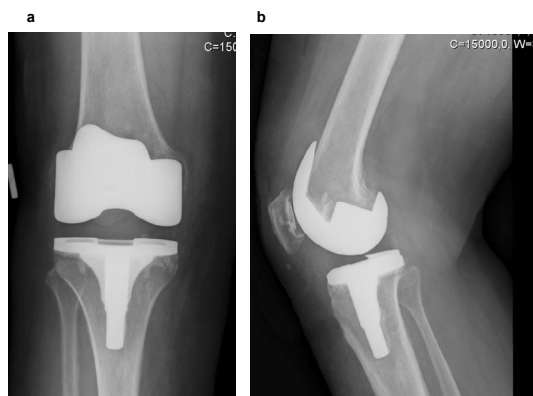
3rd postoperative year X-ray.
